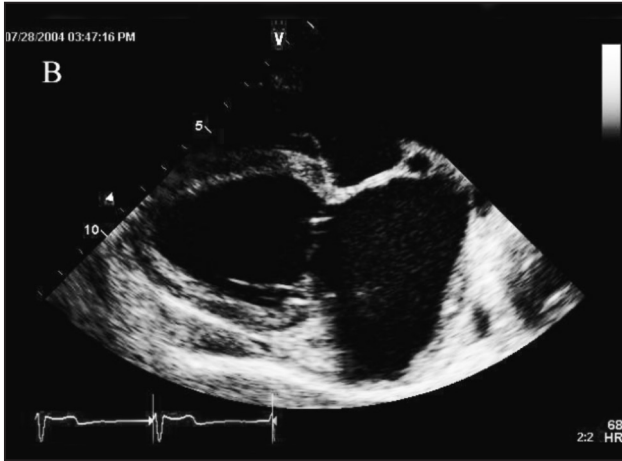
Right parasternal long-axis view (systolic frame) demonstrating left atrial enlargement, an atrial septal defect (dotted arrow), and increased thickness and abnormal content (soft tissue opacities and fluid filled pockets) of the pericardium next to the left ventricular posterior wall (solid arrows).
